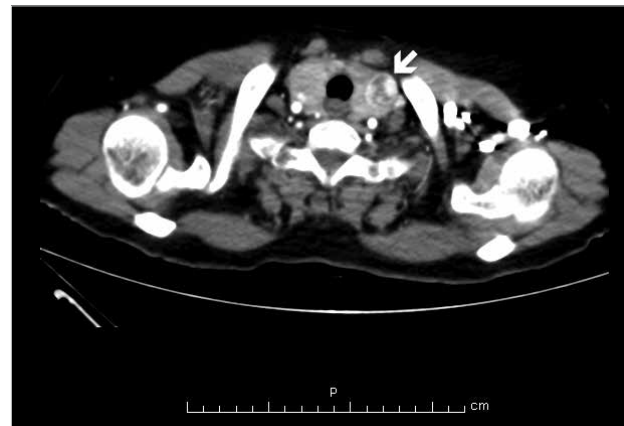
Axial computed tomography image of the neck: the white arrow indicates a mass of size 2.2 cm in the left lobe of the thyroid gland
